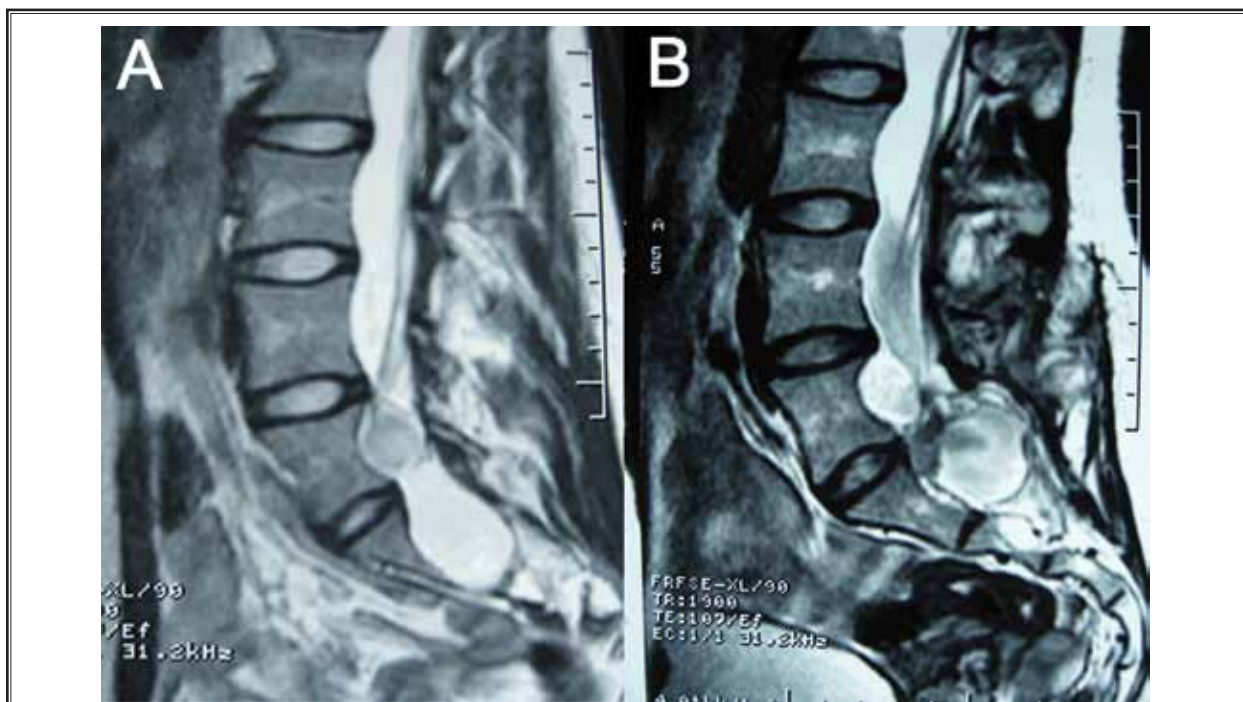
MRI study of recurrence of the cyst after microsurgical cyst fenestration and imbrication. (A) Preoperative MRI showing a cyst in sacral spinal canal. (B) Postoperative MRI showing the cyst reoccurring one year after the operation.
